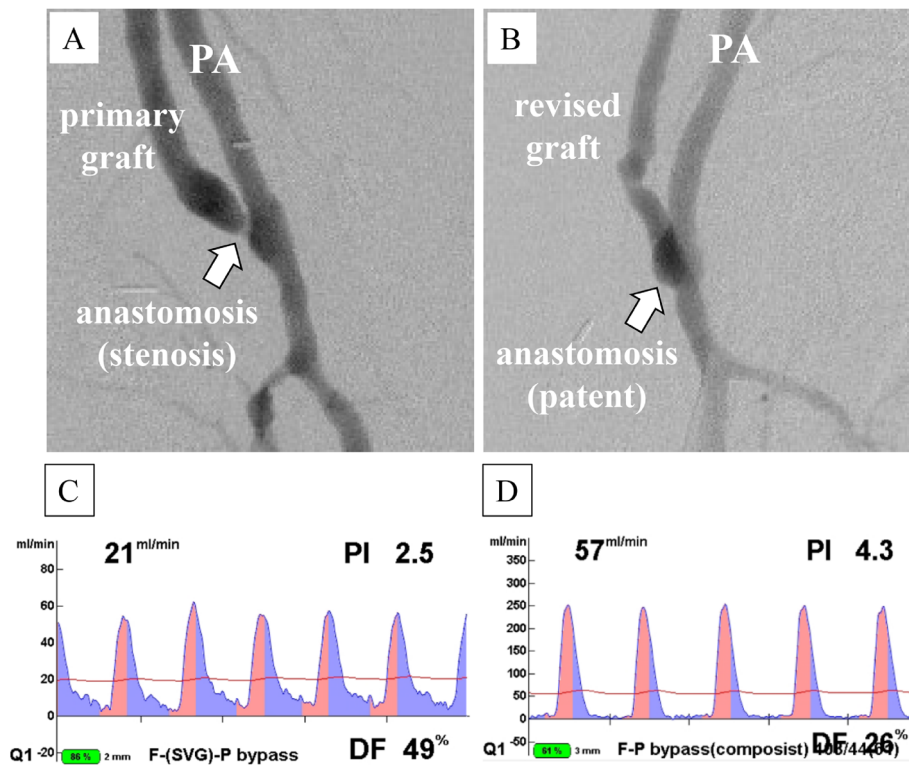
X-ray angiography and transit-time flowmetry (TTF). Femoral-popliteal bypass grafting. (A) Severe anastomotic stenosis (arrow). (B) No stenotic anastomosis (arrow). (C, D) Graft flow measurements using TTF during primary surgery (C) and revision surgery (D). PA: popliteal artery
